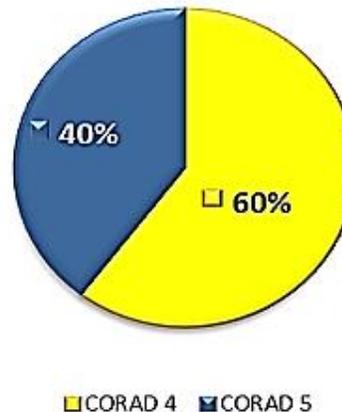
CT findings of the chest.
